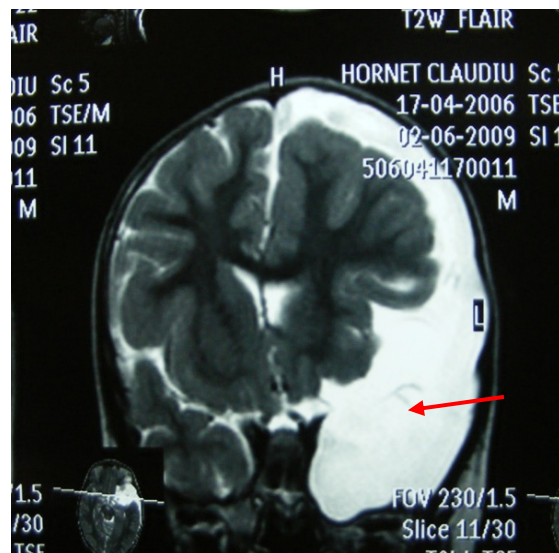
MRI- aspect of Gallasi III left cerebral hemisfere arachnoid cyst with middle line shift
